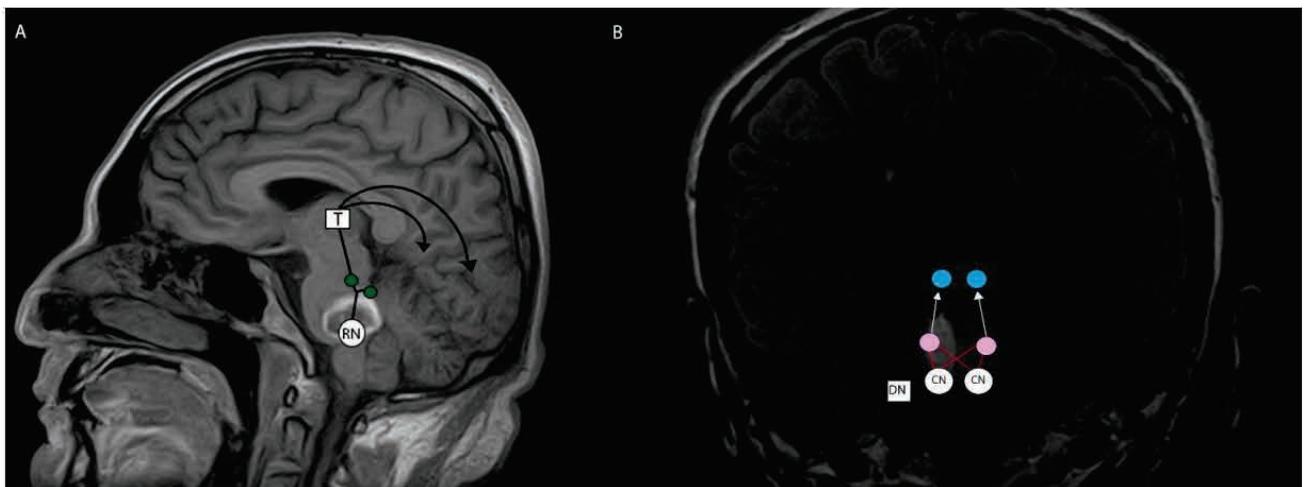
A: T1 sequence, sagittal section, showing the main pathway causing neurotransmitter imbalance in peduncular hallucinosis (RN – dorsal raphe nucleus; T – thalamus; green dots – pedunculo-pontine and laterodorsal tegmental nuclei). B: T2 FLAIR sequence, coronal section, showing main pathways involved in central auditory dysfunction caused by brainstem lesions (white dots – CN – ventral cochlear nuclei; pink dots – superior olivary complex; blue circle – inferior colliculi; DN – dentate nucleus)
